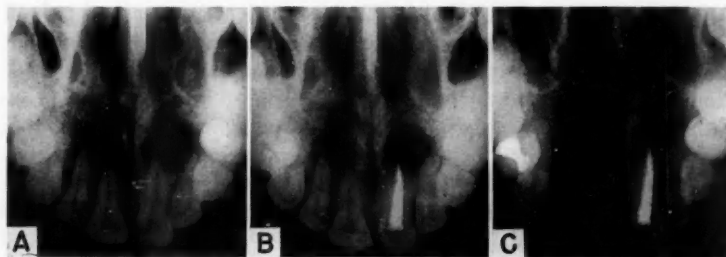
Apical periodontal healing following conservative treatment. A, Diagnostic roentgenogram; B, canal filled; C, subsequent healing.
